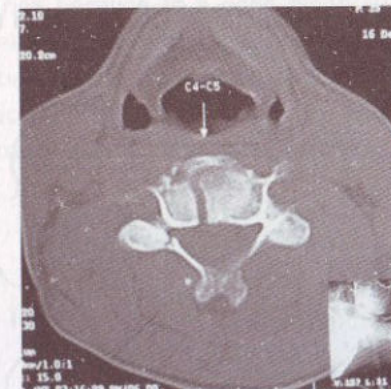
CT scan cervical spine showing burst fracture of vertebral body
